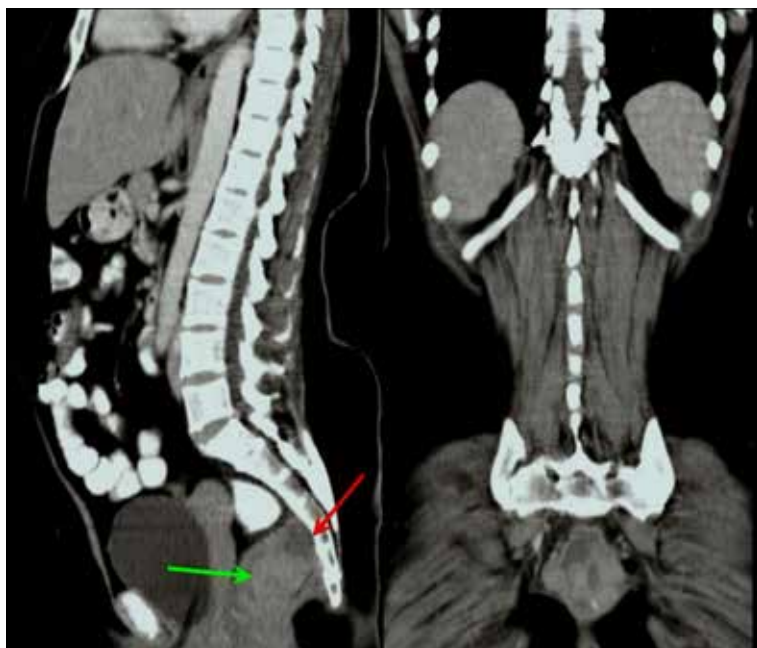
Contrast-enhanced CT scan of the pelvis in sagittal and coronal reformats reveals a solid, moderately enhancing presacral tumour (green arrow) causing mild scalloping of the sacrum (red arrow).
